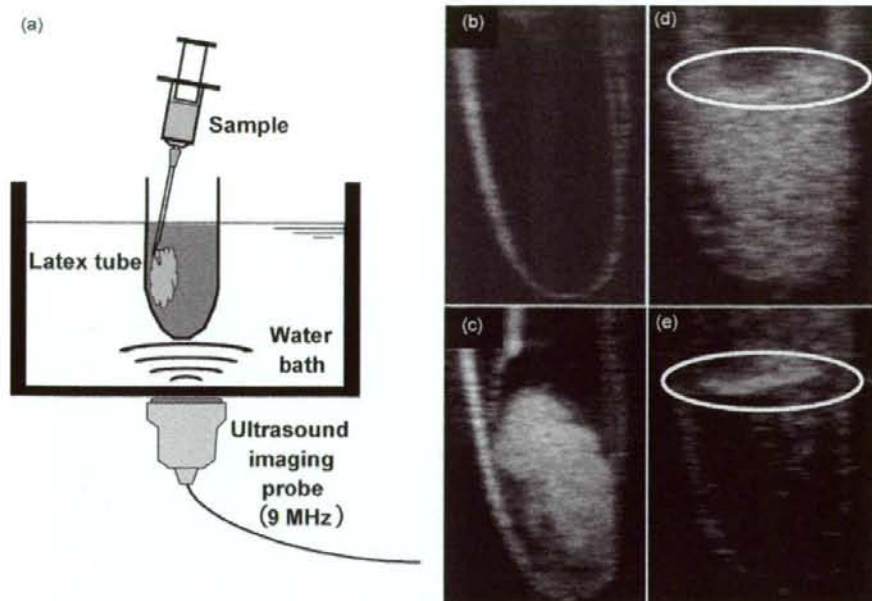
Ultrasonography of Bubble liposomes. The ultrasonography method for observing Bubble liposomes is shown in (a). PEG-liposomes (b) or Bubble liposomes (c) were injected into a PBS-filled latex tube in a water bath and the samples were observed with ultrasonography. To confirm the disruption of the Bubble liposomes, the Bubble liposomes were observed with ultrasonography before (d) and after (e) ultrasound exposure (2 MHz, 2.5 W/cm<sup>2</sup>, 10 s).
